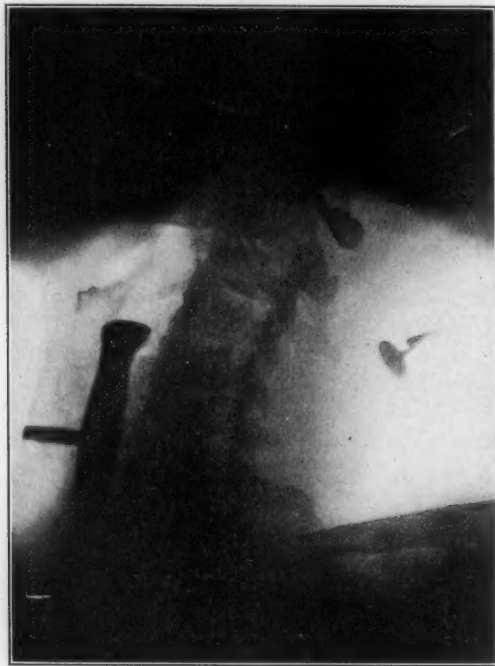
Radiograph of patient, Case 7, with aluminum intubation tube in situ. The screw stem which is inserted after intubation, per os, is to preserve a fistula and to prevent bechic extubation.
